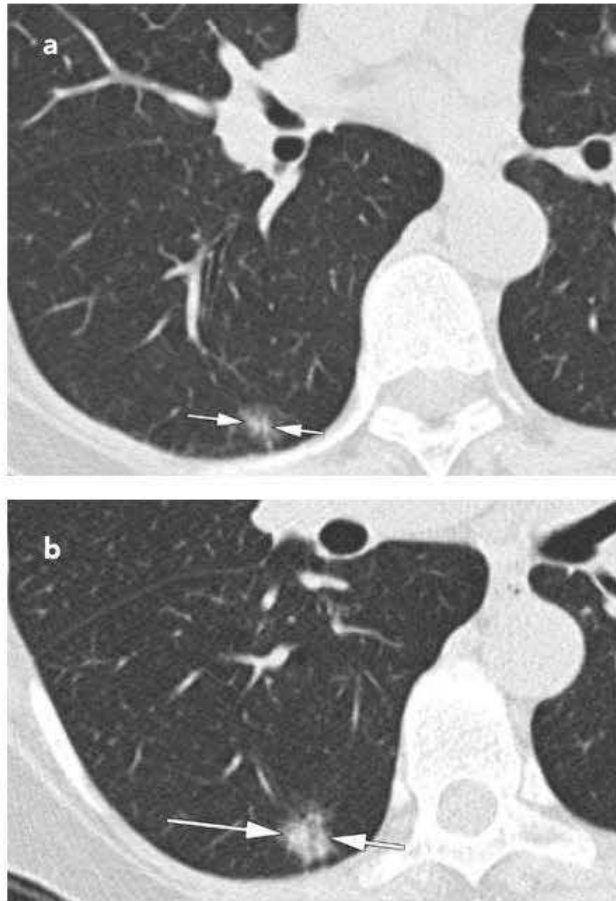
CT scans in a 60-year-old woman undergoing low-dose lung cancer screening CT. (a) Baseline scan shows a right lower lobe part-solid nodule measuring 11 mm with 5-mm solid component (arrows). Nodule was classified as Lung-RADS category 3. (b) Scan obtained at second annual follow-up shows that nodule grew to 17 mm with 7 mm solid component (arrows). Malignancy was subsequently diagnosed.
